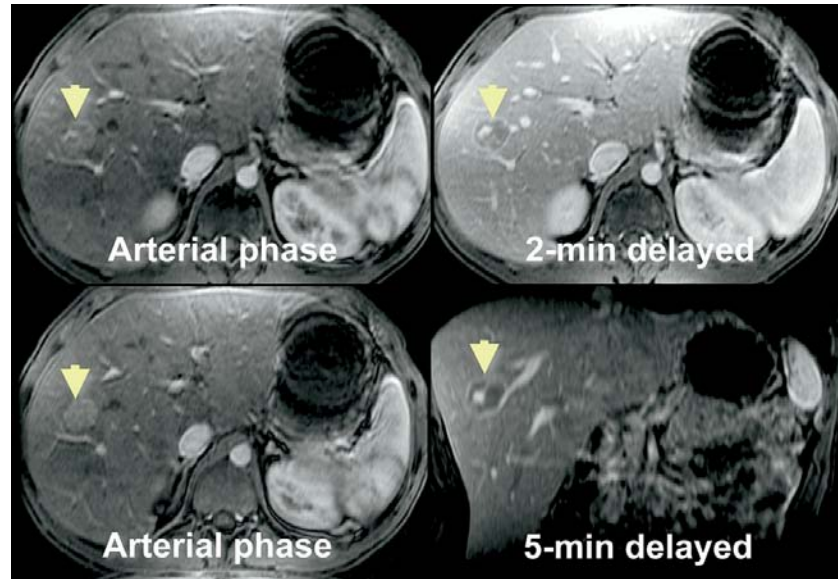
MRI features of HCC showing arterial phase enhancement (top and bottom left) followed by hypointense signals on the venous face (top and bottom right).
